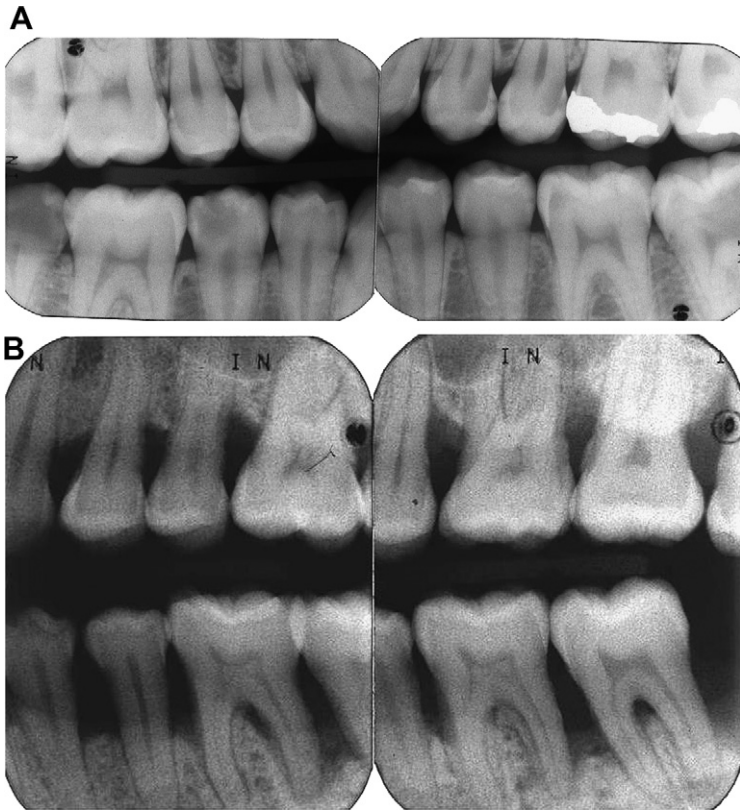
(A) Horizontal bite-wing radiographs show that the height of the alveolar bone is in a normal position. (B) Vertical bite-wing radiographs demonstrating vertical and horizontal bone loss.
